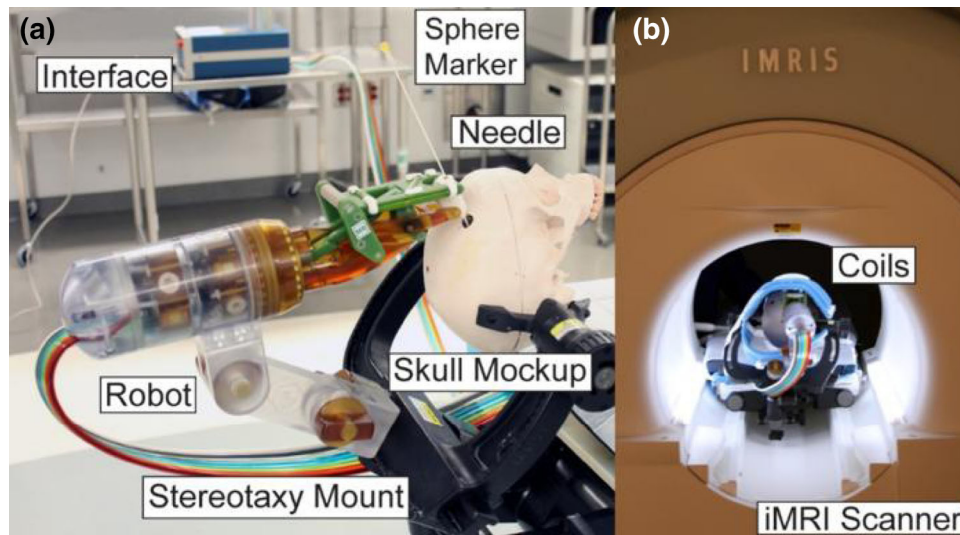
Robot and skull (a) on the table and (b) inside the MRI scanner.<sup>44</sup>
